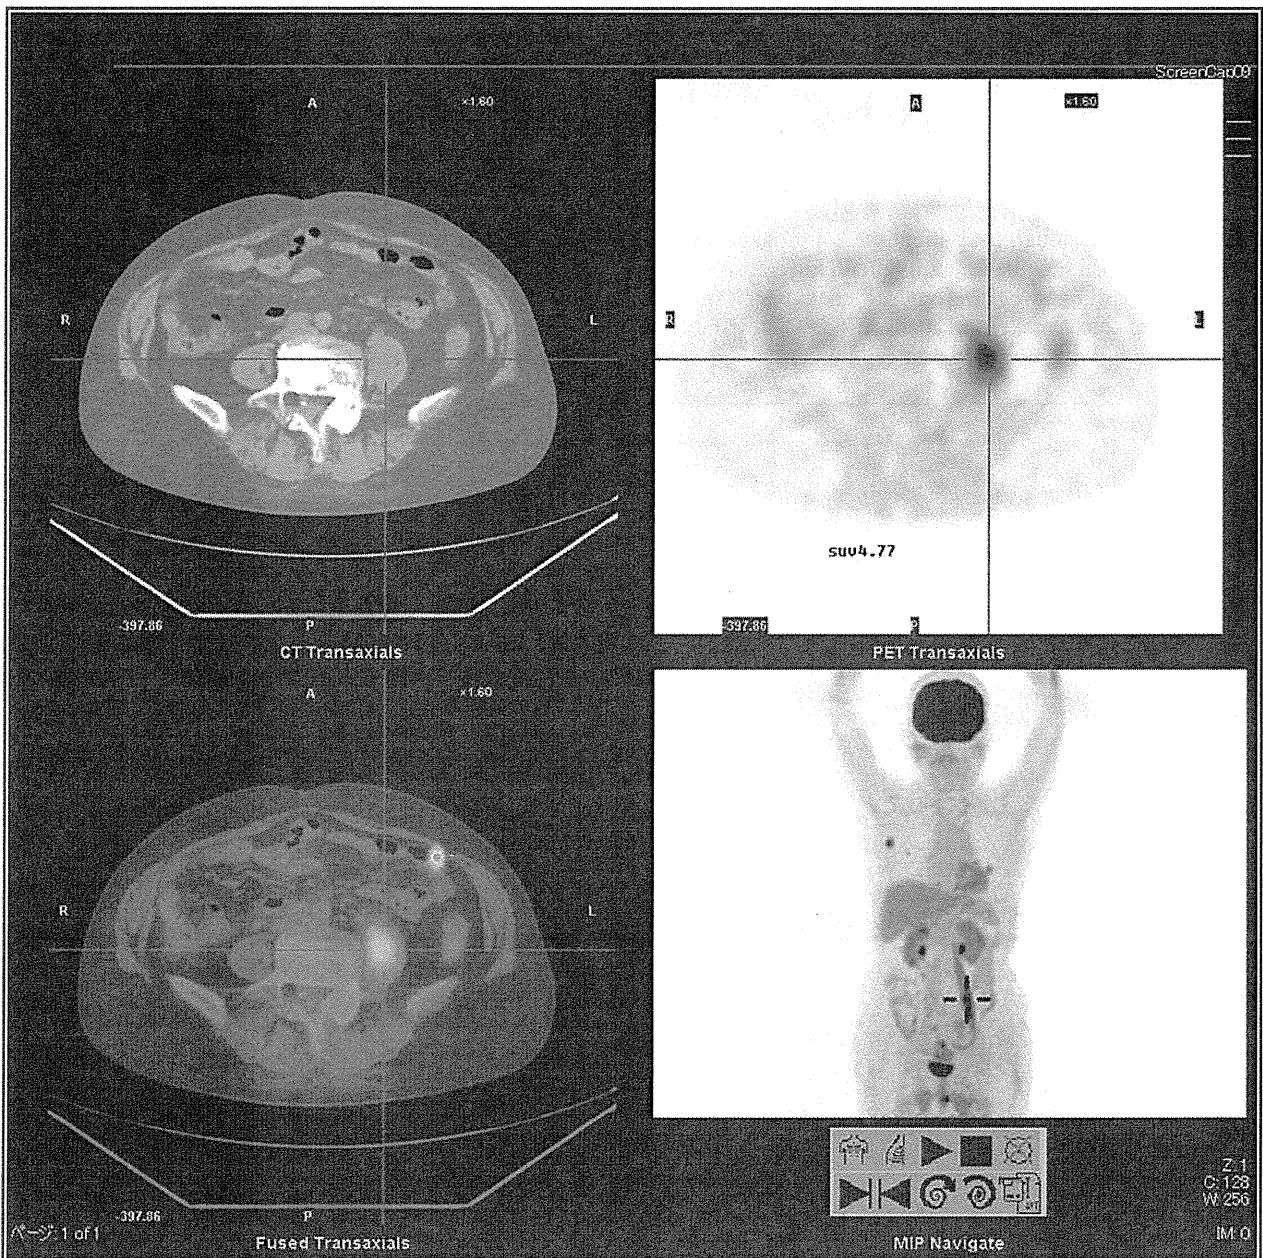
Positron emission tomography/computed tomography of Case 3 on admission.
